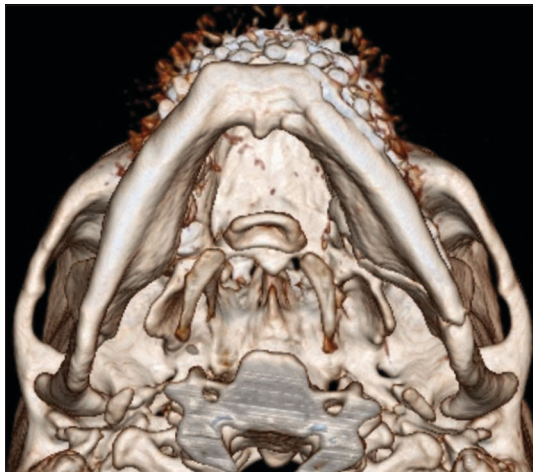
Postoperative axial three-dimensional (3D) computed tomography-scan view of the inferior border of the Left angle and body fractures fixation using a biplane 3D miniplate for angle fracture. Note the appropriate horizontal alignment of the angle fracture according to the inferior mandibular border across the fracture line.
